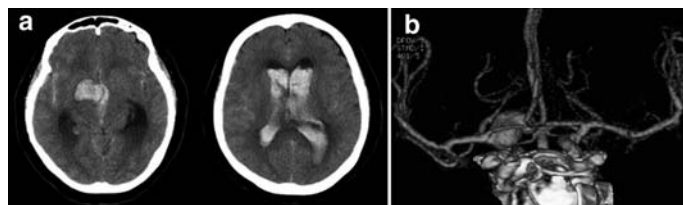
A 64 year-old woman had a grade 4 subarachnoid hemorrhage due to rupture of a right IC large aneurysm. (a) CT demonstrating a small intracerebral hematoma and massive intraventricular hemorrhage. (b) 3D CT angiography demonstrating a ruptured right IC large aneurysm with a large bleb considered as a rupture point
